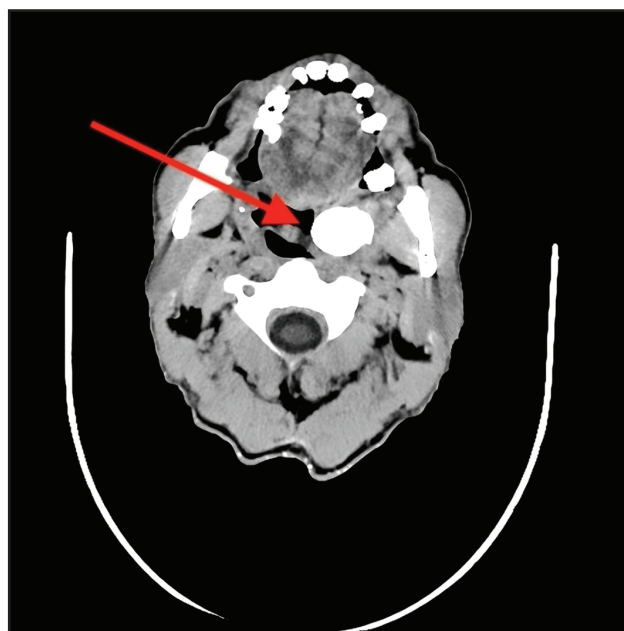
Axial CT image slice revealing the cylindrical calcified lesion located in the left tonsil with pseudonodular formations.
